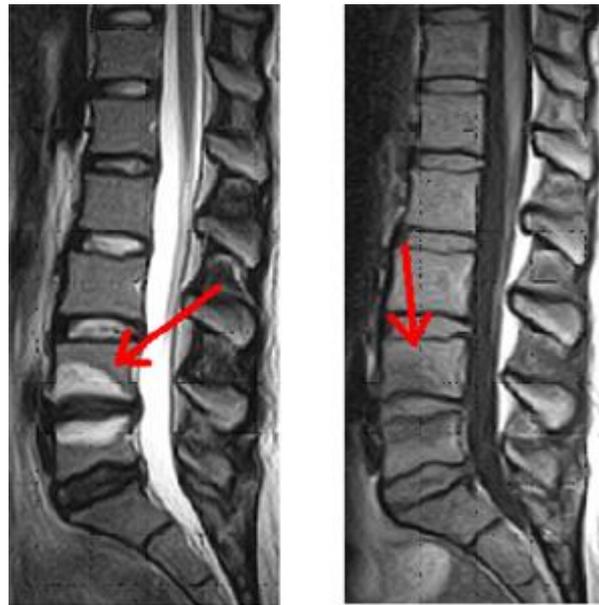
Modic changes in lumbar vertebral body end-plates on MRI.
